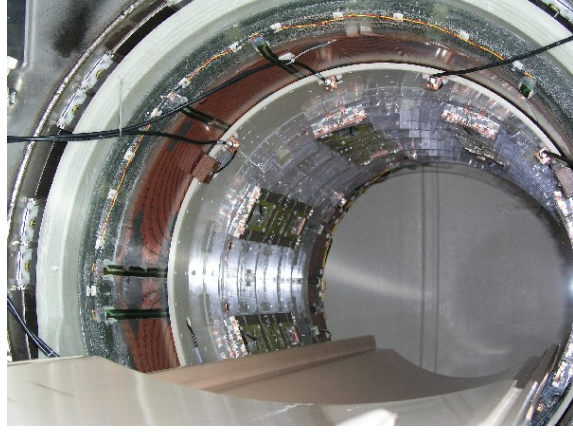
8-channel PTx array installed within the Philips MRI system. The coils elements can be seen going around the inside of the bore.
